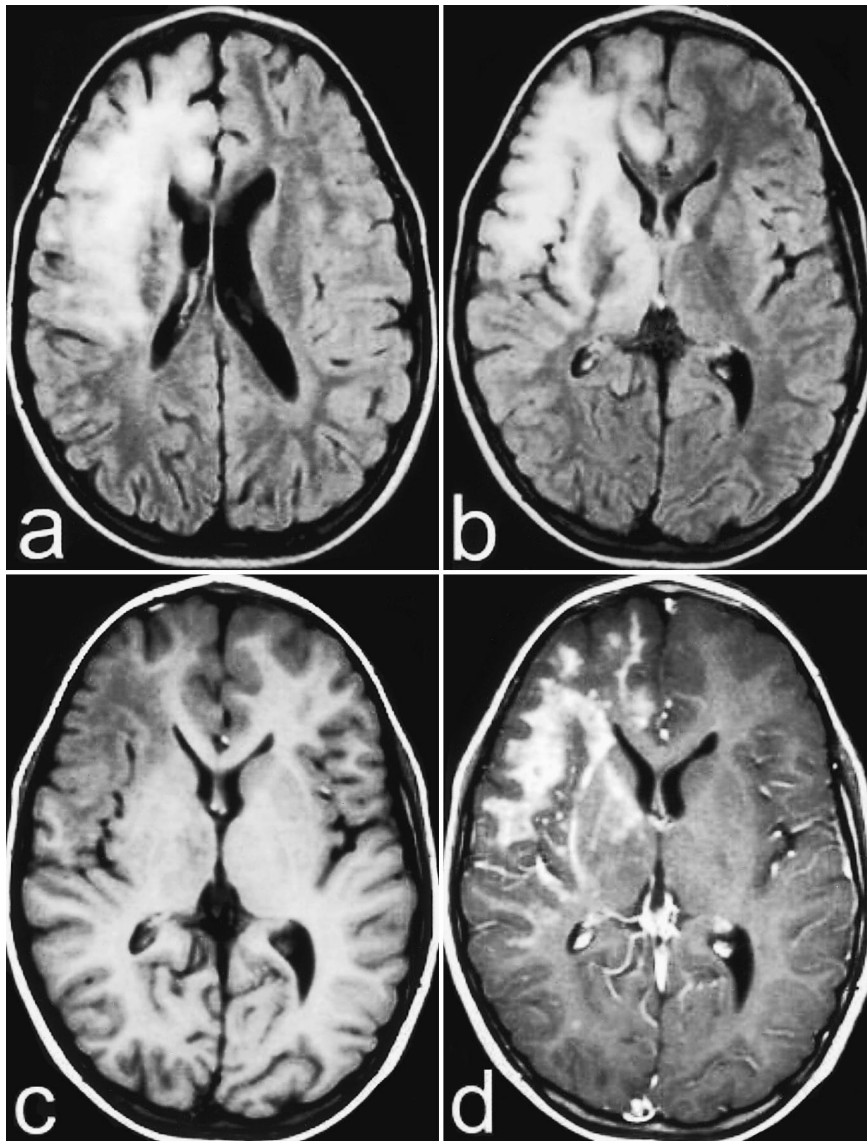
a to d a and b Axial MRI T₂-weighted, FLAIR (TR 9999, TE 105, TI 180) showing extensive hyperintense lesions involving right frontal white matter, internal capsule and right thalamus. The gray matter is spared. c and d Axial MRI (T₁-weighted, TR 600 TE 14, TR 560 TE 17). The lesions appear as hypointense areas. After gadolinium injection, strong enhancement is seen within the white matter. Interestingly, a dual enhancement pattern is present consisting of areas of diffuse enhancement interposed with multiple areas of punctate enhancement.
